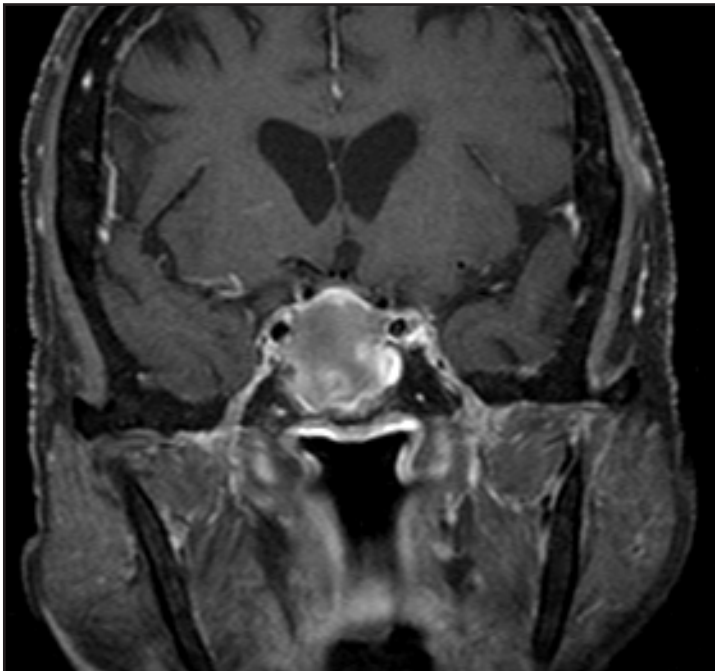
An MRI of brain with contrast showed a sellar/suprasellar mass with heterogeneous signal intensities suggestive of hemorrhage into a pituitary adenoma and consistent with pituitary apoplexy.
